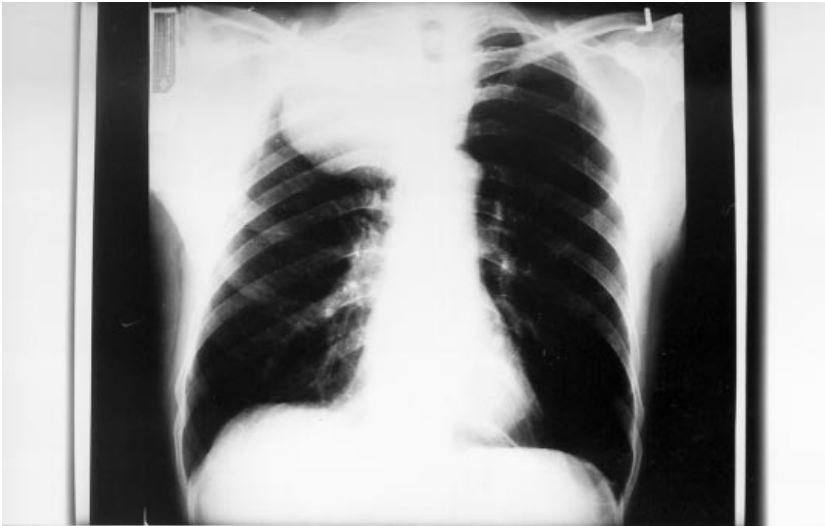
Chest x-ray of the patient showing a well circumscribed mass at the extreme apex of the right lung.
